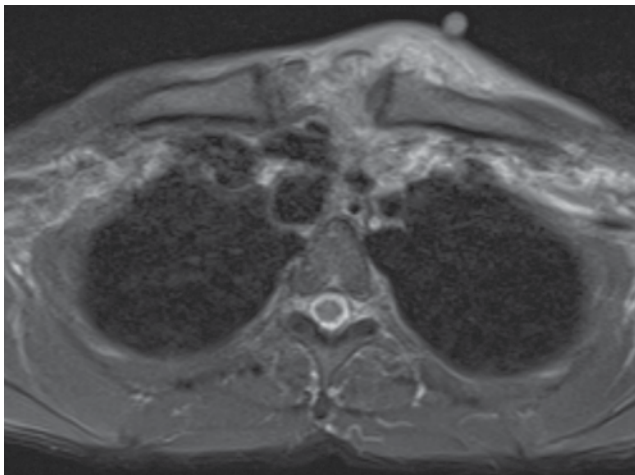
Sternal MRI scan showing left-sided sternal osteomyelitis, with overlying soft tissue inflammation.
